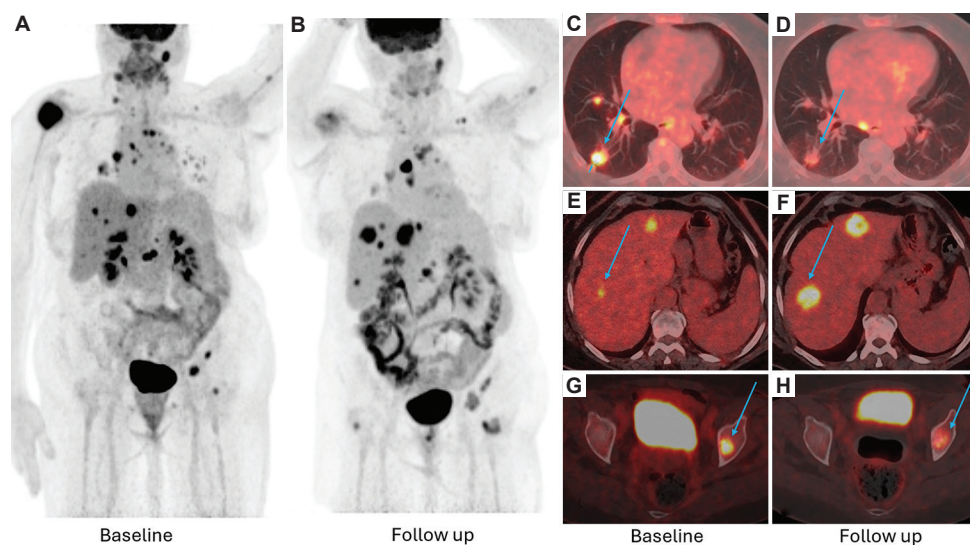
Positron emission tomography/computed tomography (PET/CT) imaging of a 60-year-old woman with lung cancer with multiple metastases. (A and B) Maximum Intensity Projection (MIP) images of ¹⁸F-FDG-PET/CT at baseline (A) and ¹⁸F-FDG-PET/CT at follow-up after three cycles of chemotherapy (B) display mixed responses in multiple metastases. (C–H) Fused PET/CT images at baseline (C, E, and G) and after chemotherapy (D, F, and H) display responses in lung and bone metastases and progression in liver metastases. Blue arrows indicate metastatic lesions in the lung, liver, and bone.
